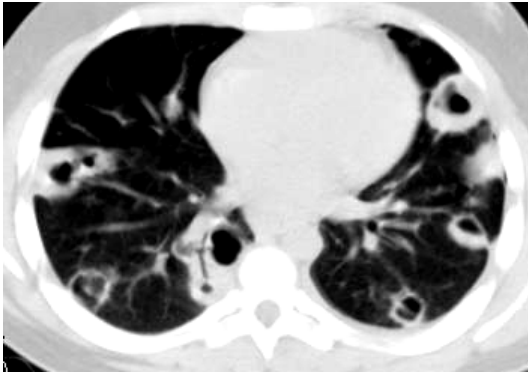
Axial CT, lung window at the level of the ventricles shows multifocal cavitating lesions at lower lobes of both lungs proved to be septic emboli. Arrow points to feeding vessel supplying the cavitory lesion.
